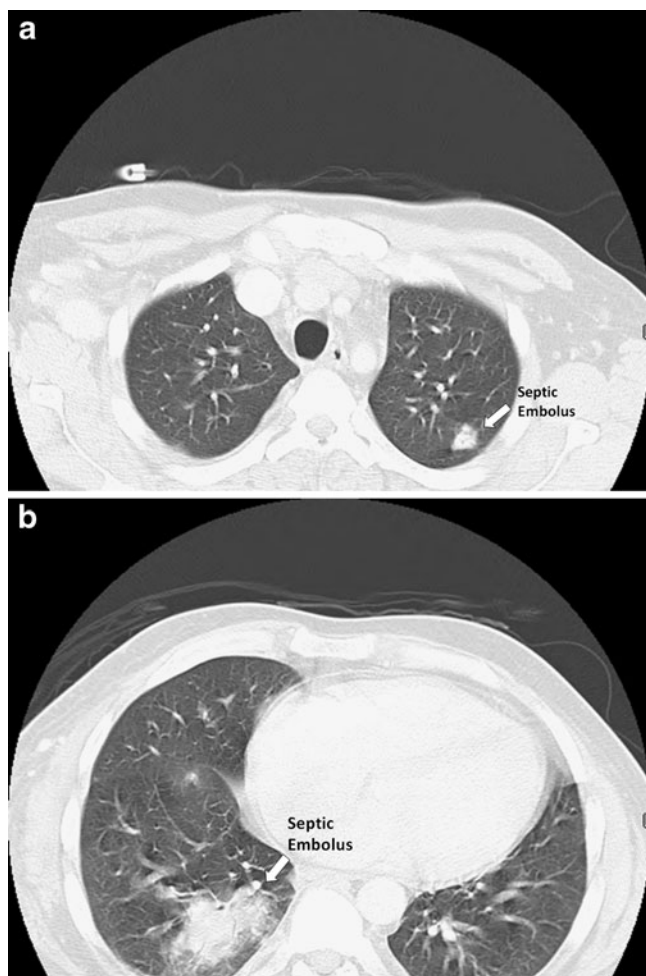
a, b CT chest demonstrating pulmonary septic emboli.
